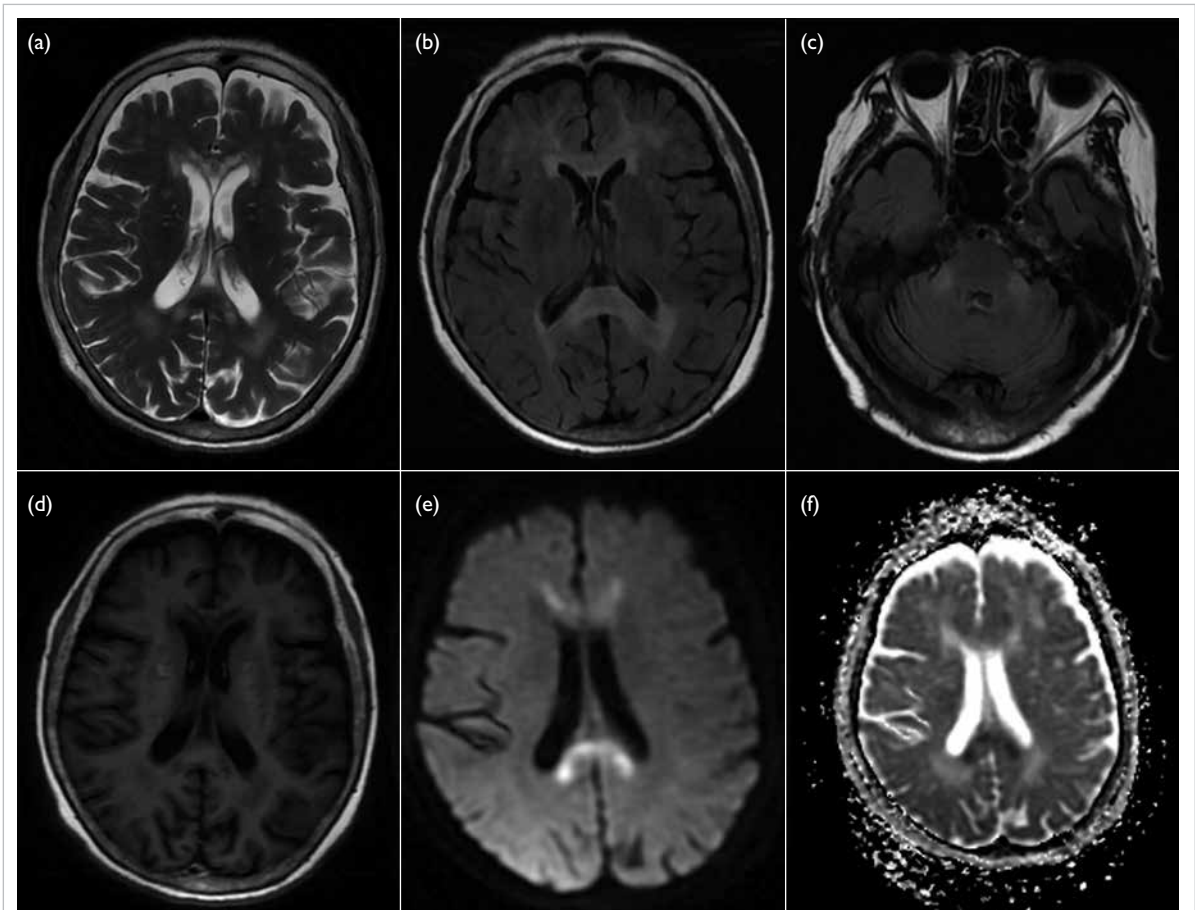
Magnetic resonance imaging of the brain showing (a) the entire corpus callosum with hyperintensity on T2-weighted imaging, (b) the entire corpus callosum with hyperintensity on fluid-attenuated inversion recovery imaging, (c) bilateral middle cerebellar peduncles with hyperintensity on fluid-attenuated inversion recovery imaging, and (d) the entire corpus callosum with hypointensity on T1-weighted imaging. The splenium was strongly hyperintense on diffusion-weighted imaging (e) and hypointense on apparent diffusion coefficient map (f). The genu was moderately hyperintense on diffusion-weighted imaging (e) and hypointense on apparent diffusion coefficient map (f)
